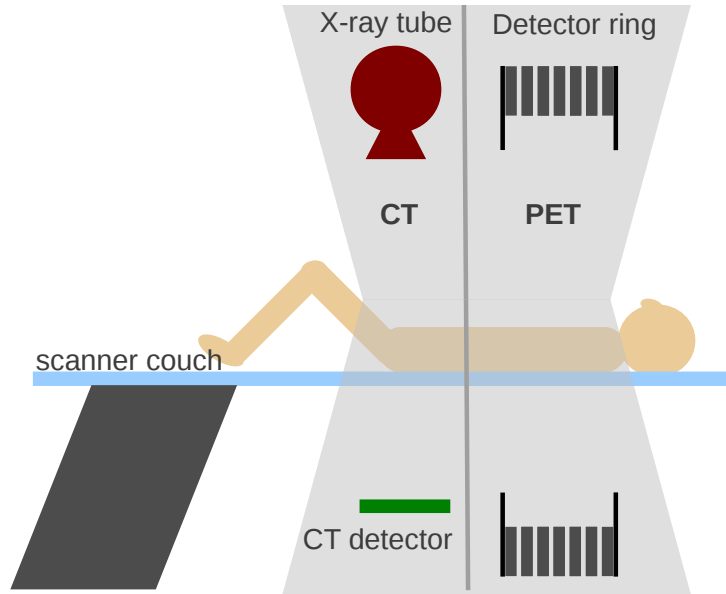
A dual modality PET/CT scanner constructed in a single gantry. The x-ray tube and CT detector rotate about the patient, and the PET detector rings are static. PET and CT images are acquired in series.
